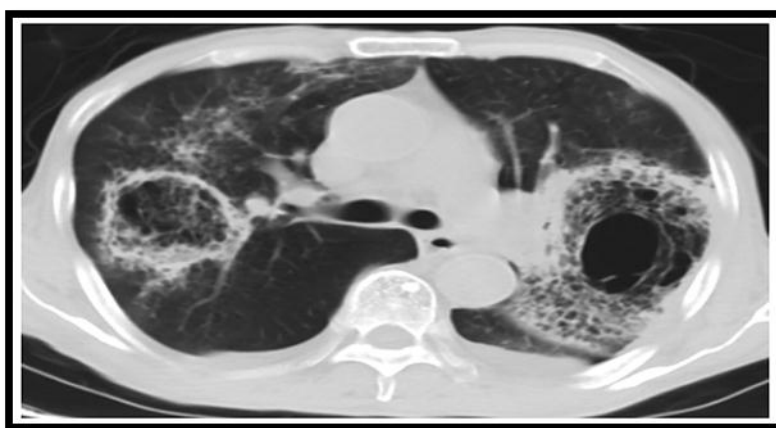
(CT scan image).
